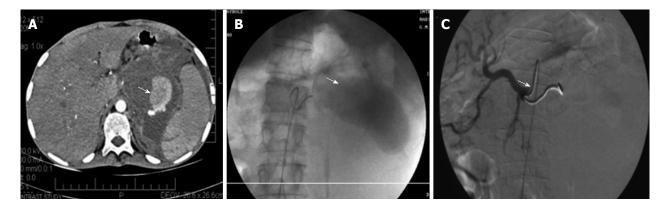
Splenic artery pseudoaneurysm before and after embolization. A: Post contrast computed tomography scan showing the pseudoaneurysm rising from the splenic artery; B: Pre embolization selective splenic arterial DSA angiography image showing pseudoaneurysm; C: Post embolization DSA image showing the coils inside the splenic artery with its resultant embolization^[92].
